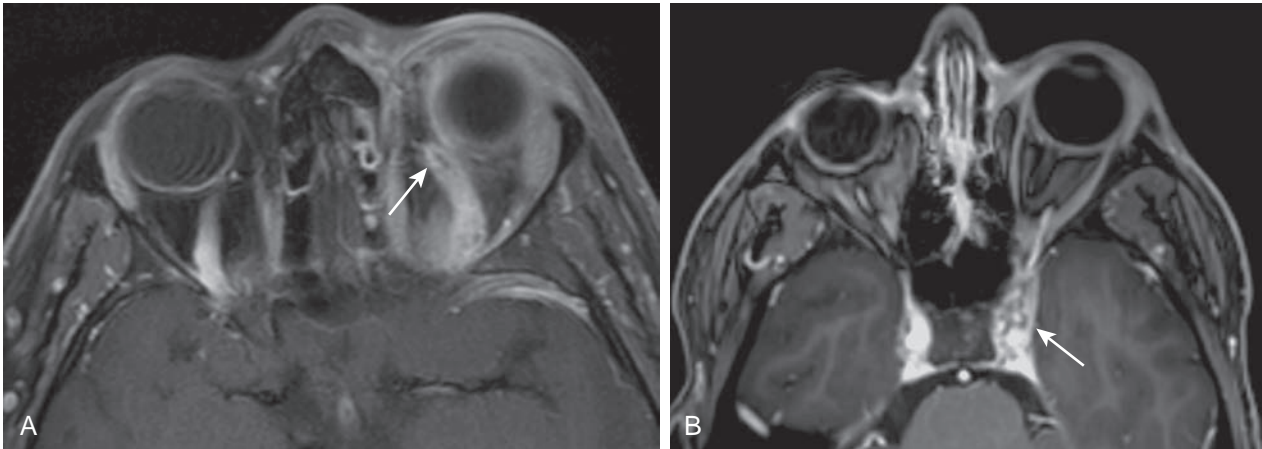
Orbital cellulitis with superior ophthalmic vein and cavernous sinus thrombosis. (A) Axial T1-weighted postcontrast fat-saturated MR image of the orbit demonstrates a focal filling defect in the superior ophthalmic vein consistent with thrombus in the setting of orbital cellulitis (*arrow*). (B) Axial T1-weighted postcontrast MR image of the brain demonstrates filling defect in the ipsilateral cavernous sinus consistent with thrombus (*arrow*).
